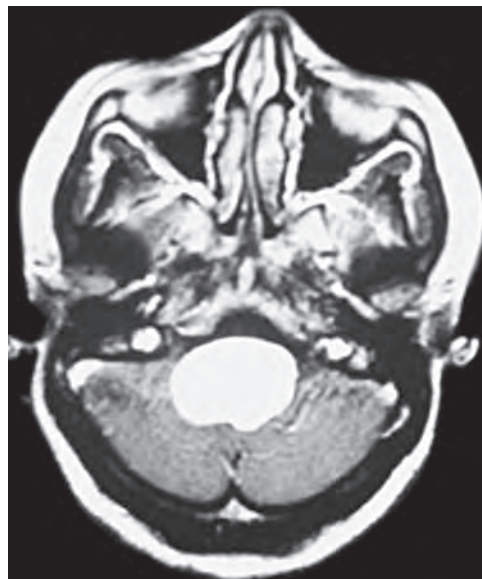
Contrast enhanced MRI of brain showing giant right vertebral artery aneurysm
